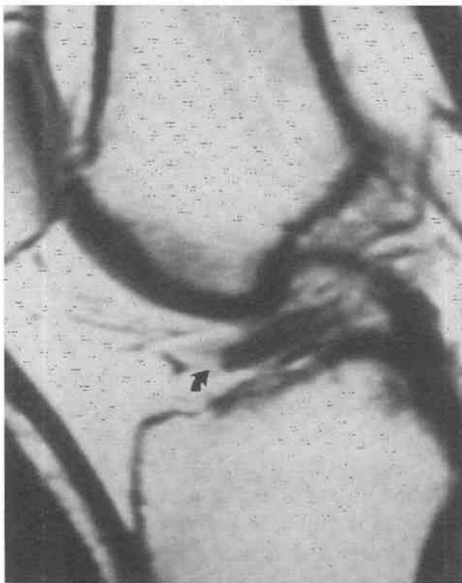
Anterior cruciate ligament (ACL) tear. Sagittal T1-weighted image shows a complete tear of the ACL, which is lying nearly horizontal within the intercondylar notch (*arrow*).
